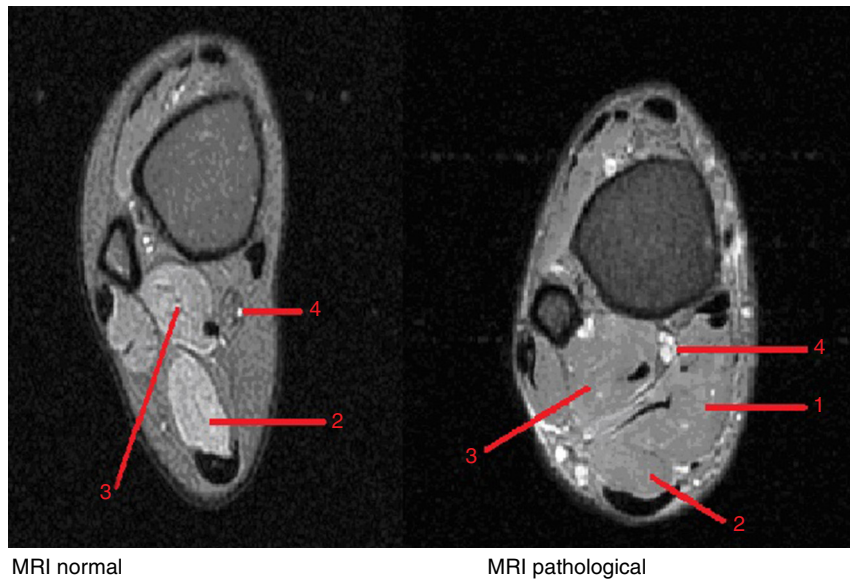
MRI. Comparative axial DP FS. Normal and pathological. 1. Accessory soleus muscle; 2. Soleus muscle; 3. Long flexor thumb; 4. Artery, vein and nerve posterior tibial.
